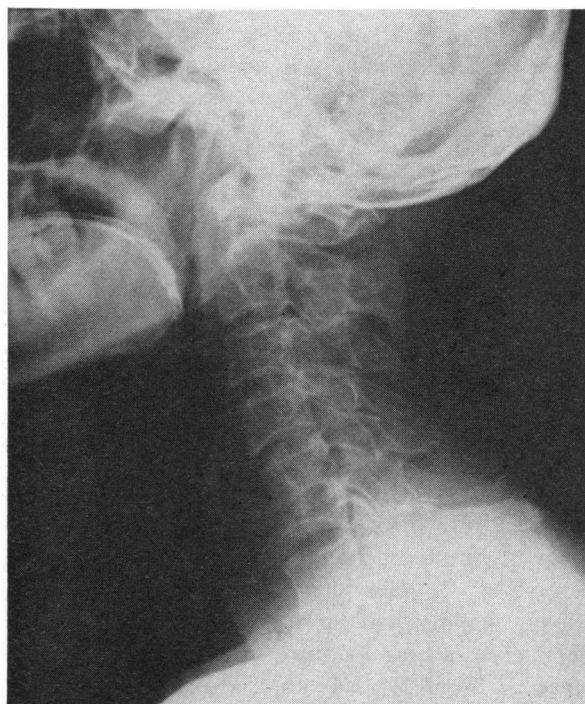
X-ray film of lateral cervical spine demonstrating the destructive process of the sixth cervical vertebra as well as apparent involvement of a portion of the fifth vertebra and the disc between the fifth and sixth.
